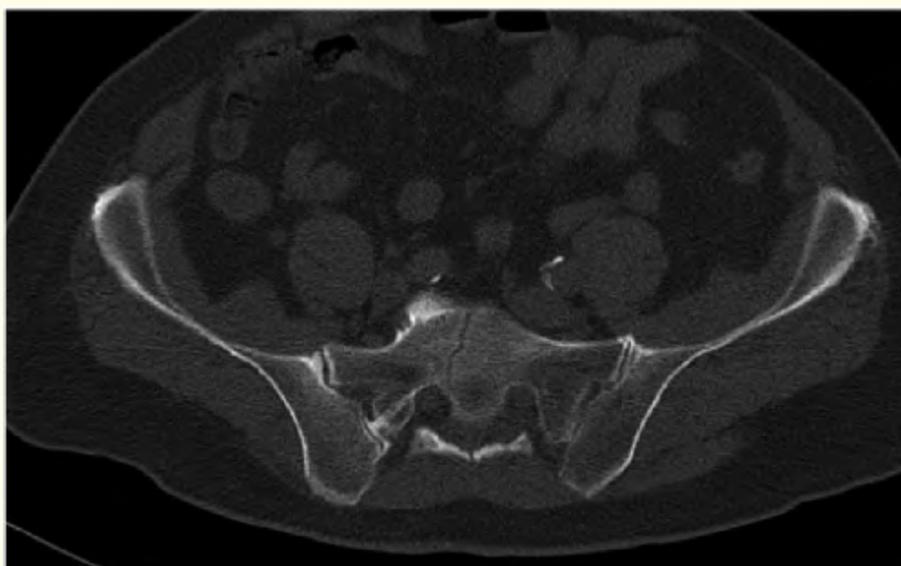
Pre-operative CT (axial plane).
